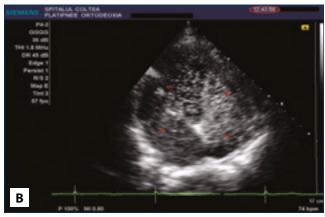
3B: Contrast transthoracic echocardiography – late appearance of contrast in the left cavities
